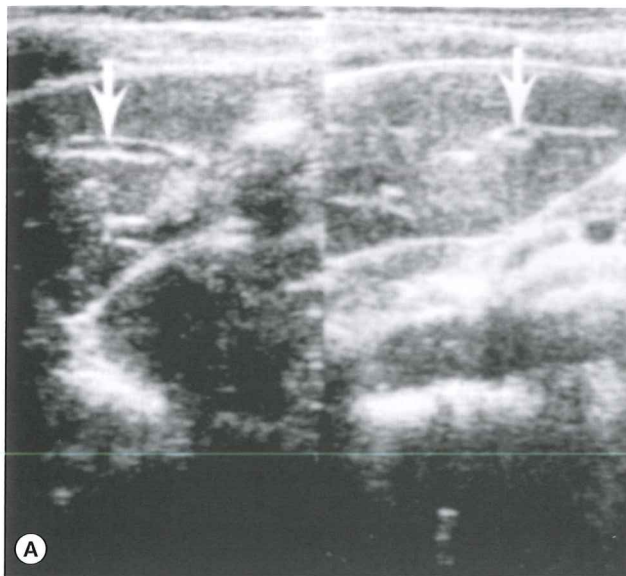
Minimal (A), moderate (B) and extensive (C) periportal fibrosis of the liver demonstrated by ultrasonography. The arrows point to typical lesions.
